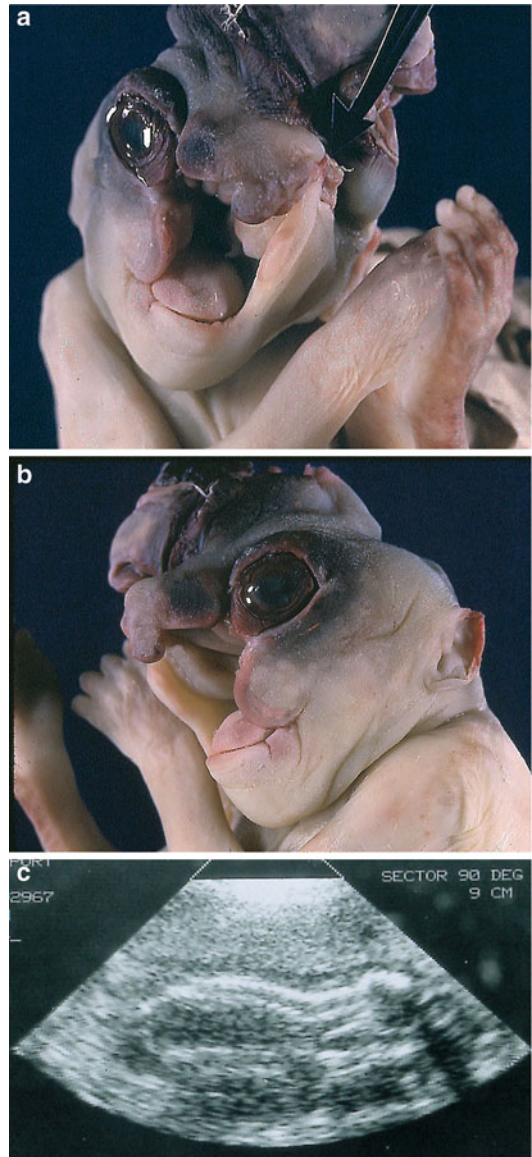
(a–c) A fetus with marked craniofacial defects and the site of amniotic band attachment at the base of the skull. The fetus also had amputation of the distal left great toe (not shown). Prenatal ultrasonography showed a complex structure arising from the top and front of the craniofacial region
